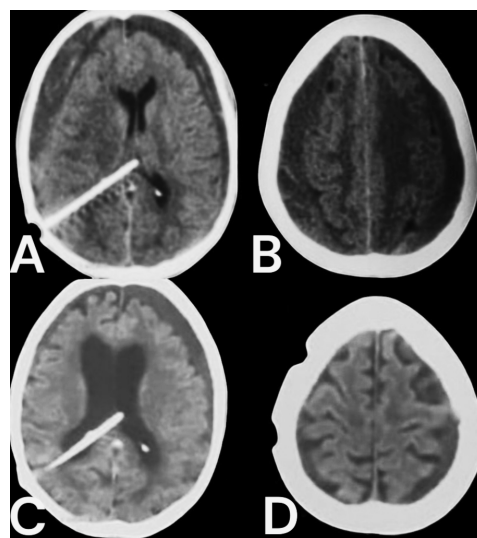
Female patient, 75 years old and diagnosed as iNPH. She was operated for ventriculoperitoneal shunt using low pressure valve. After about two months of improvement, she experienced gradual deterioration of motor power, urine control and consciousness. Following hematoma evacuation and shunt pressure upgrading to medium pressure she recovered again. (A and B) axial CT brain cuts revealed bilateral chronic subdural hematoma with drained ventricles (C and D) CT brain axial cuts after hematoma evacuation and shunt valve pressure upgraded for medium pressure shunt.
